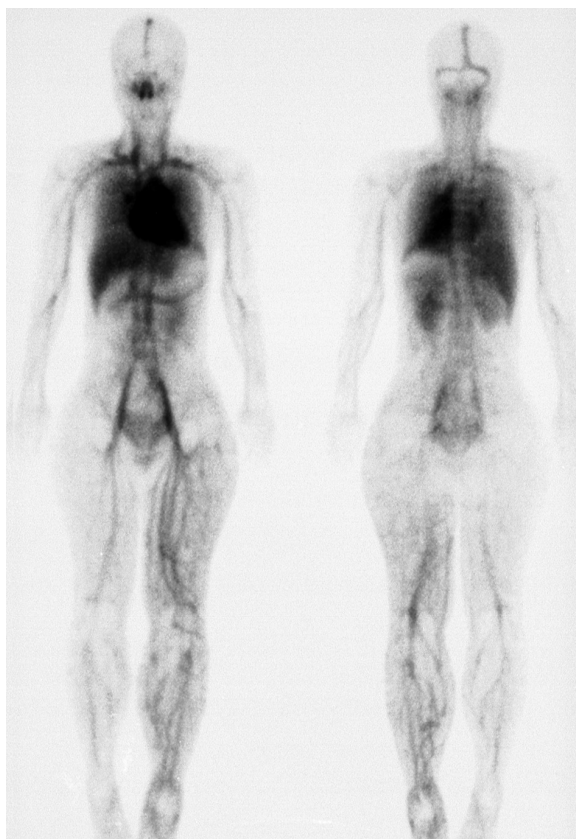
Hemihypertrophy of the left leg as well as a capillary hemangioma around the left ankle by radioisotope scintigram.
